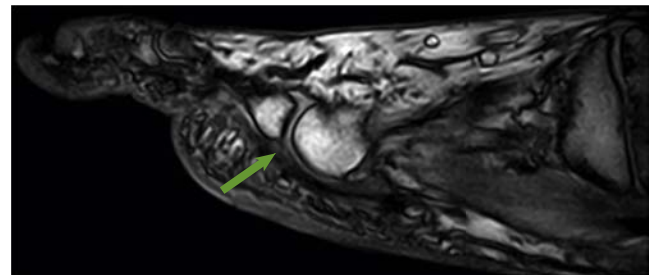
Sagittal MRI cut demonstrating a plantar plate tear (arrow). (Courtesy Lowell Weil Jr, DPM)
